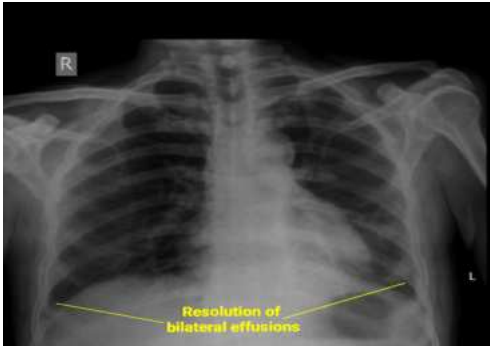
Follow up Chest X-RAY
